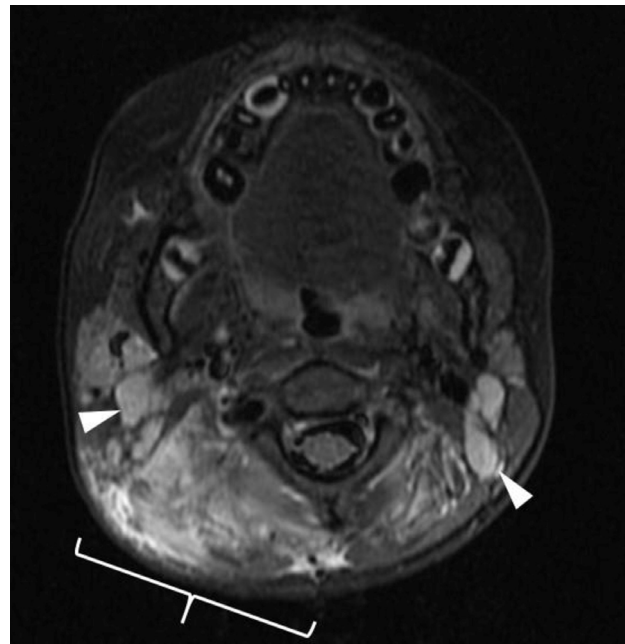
Axial magnetic resonance imaging (STIR) scan through the upper cervical spine and mandible showing high signal oedema in the posterior right paraspinal muscles of the neck without abscess (bracketed). Reactive lymphadenopathy is also seen (arrowheads).
